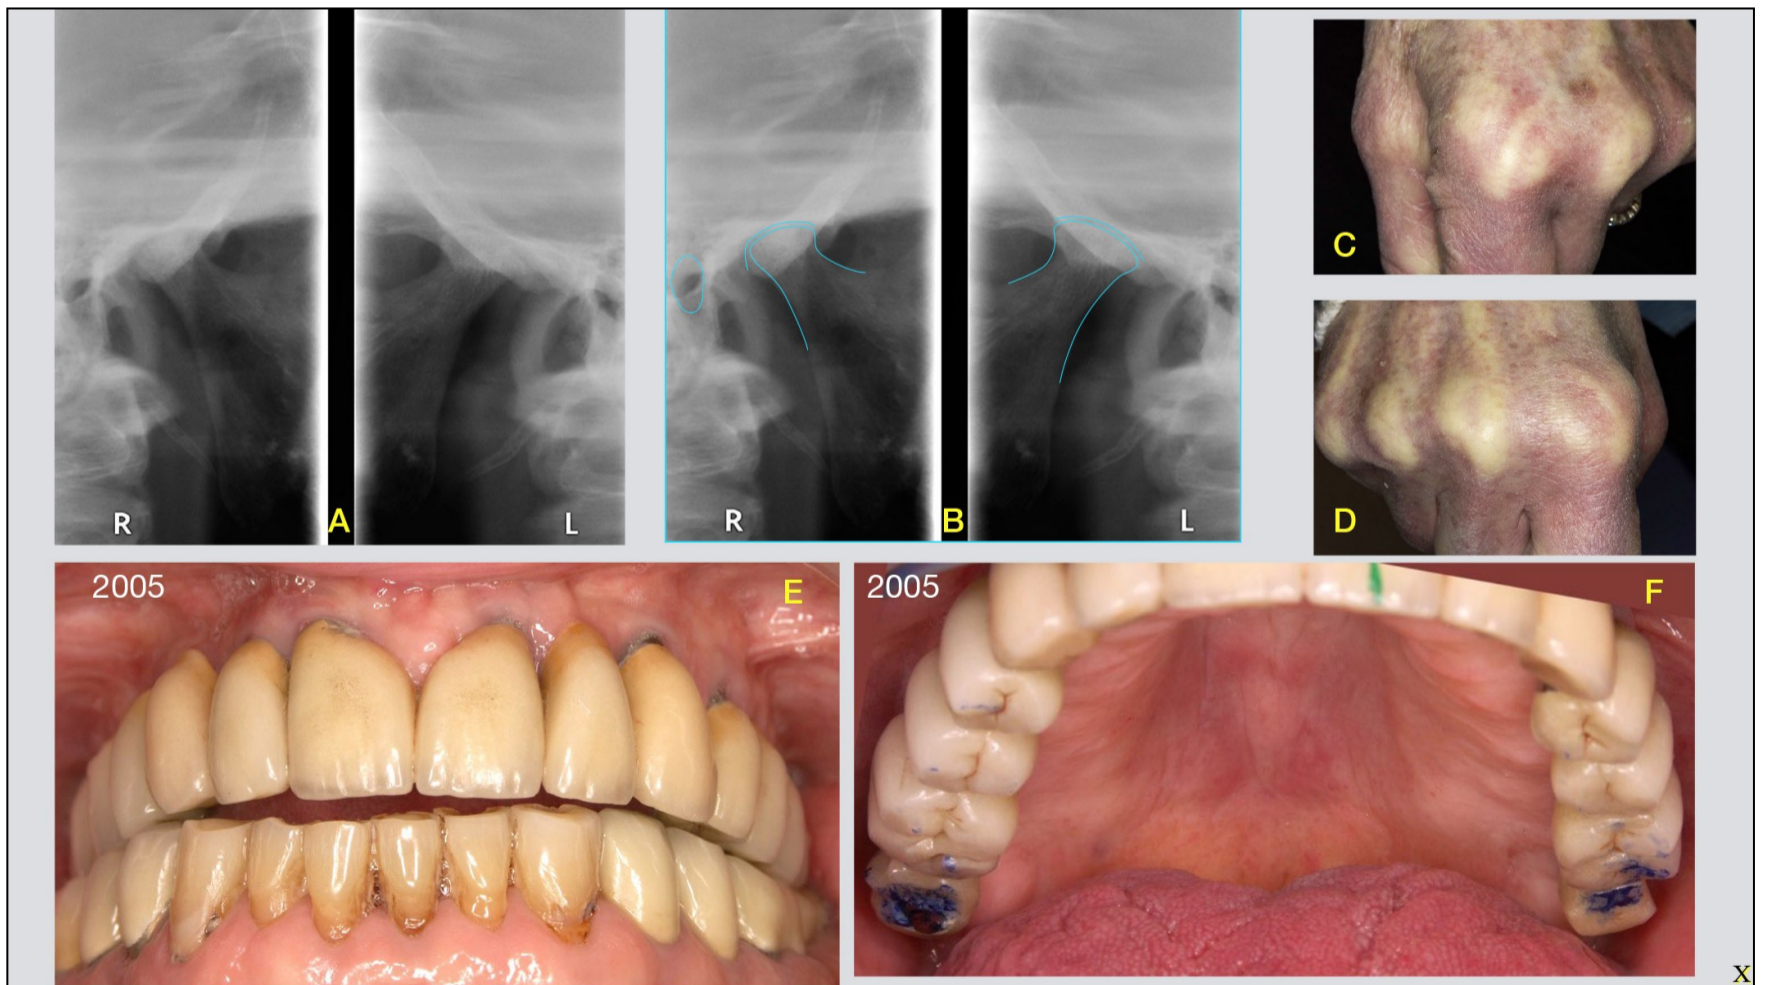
7 months later the patient returns to control, with a complete anterior open bite. The only MIO contacts are located on M2 pairs. She shows me her hands, which are rapidly deforming, and tells me that they result from progressive rheumatoid arthritis. CT scans show the heads of the collapsed mandibular condyles that are responsible for the open bite, which is itself progressive.
